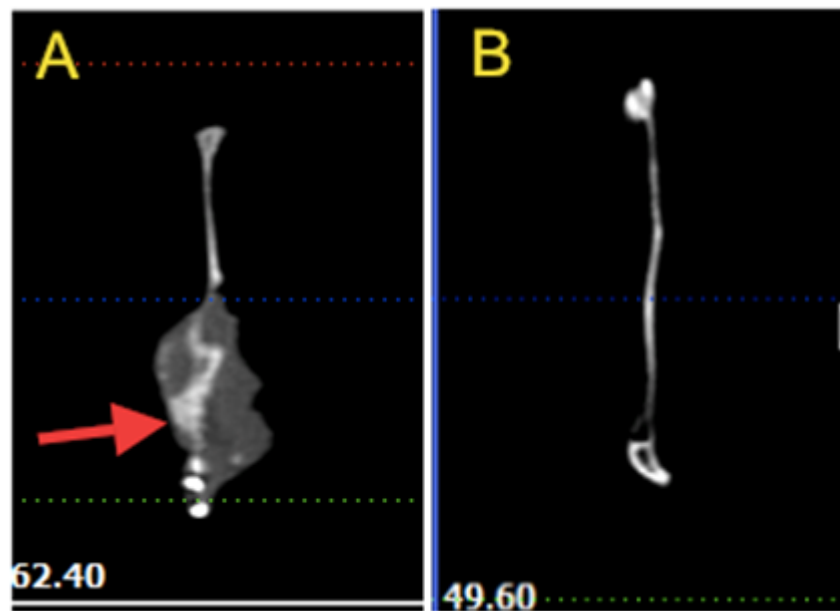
Coronal sections of the CBCT through the ramus of the mandible for case 151; A) shows the area of bone regeneration (red arrow). B) Shows the contralateral side, the thickness of the slices is 2 mm.
